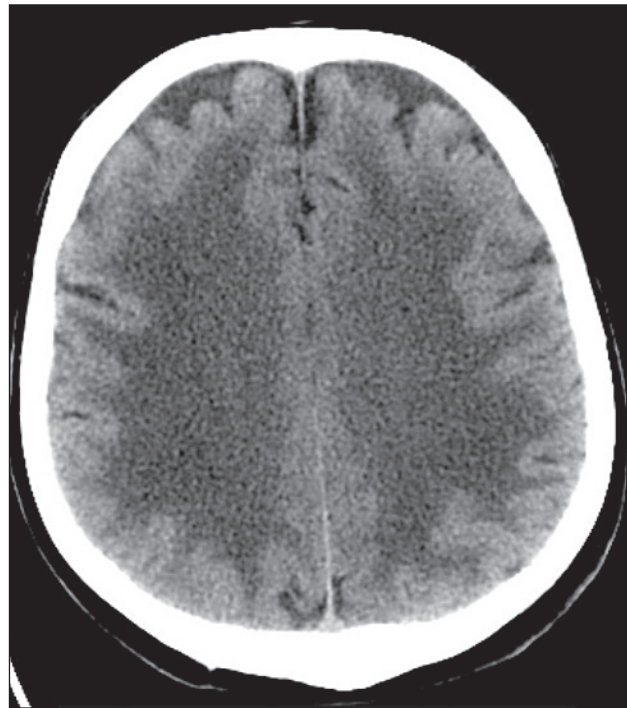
An axial CT imaging of brain demonstrates hypodensity throughout the cerebral white matter
